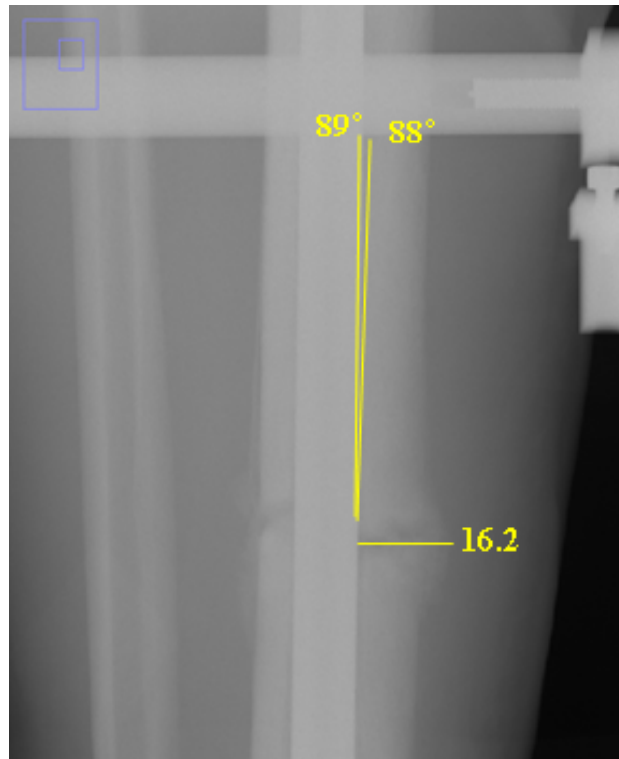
AP X-ray image showing the position of measurements for the angular and lateral offsets measured manually using Image J.
